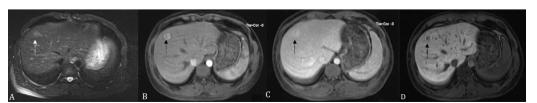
Criteria for hepatocellular carcinoma during MRI scans. (A) Plain scan phase. (B) Enhanced arterial phase. (C) Enhanced portal phase. (D) Enhanced hepatobiliary-specific phase. An arrow indicates enhancing nodule (hepatocellular carcinoma).
